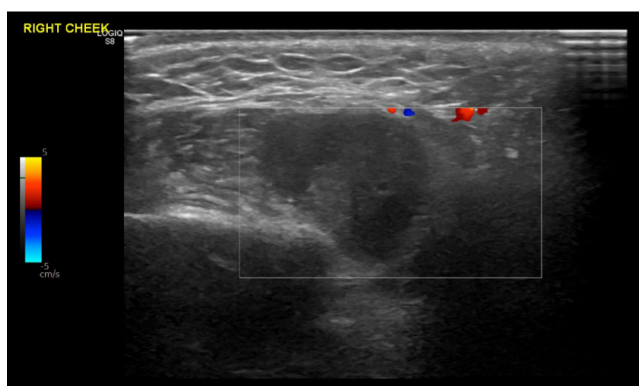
Doppler ultrasound image of the transverse right cheek demonstrating no measurable vascularity of the lesion
